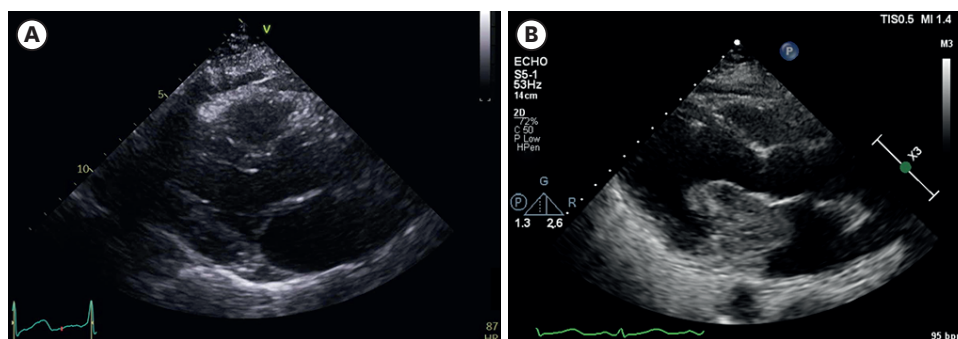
Comparison of echocardiographic images. (A) No abnormal mass in LA 10 months ago. (B) LA mass suggestive of myxoma. LA: left atrial.
